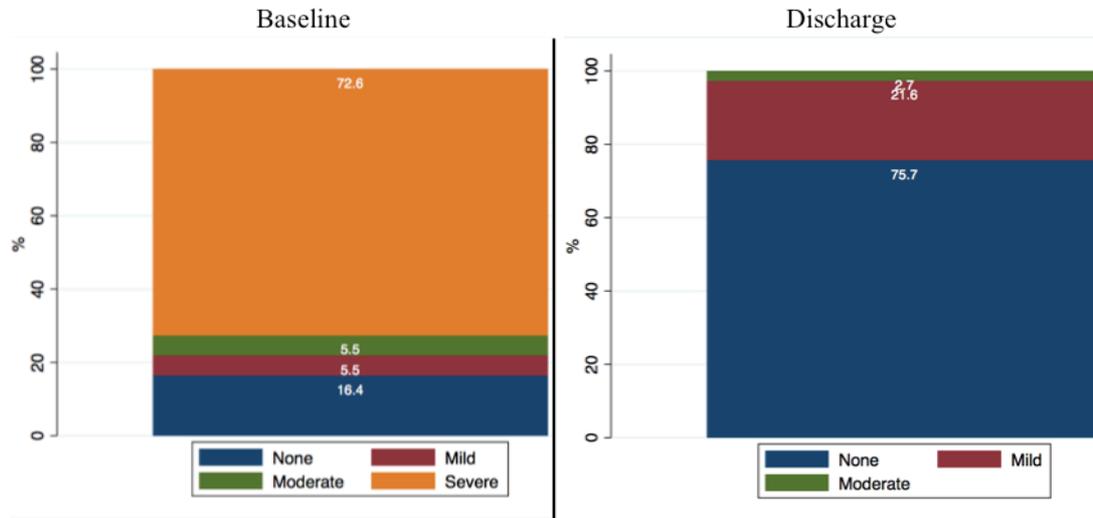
Comparison of basal and pre-discharge of tricuspid regurgitation (A), “pulmonary” regurgitation (B) percent distribution of differential grading in the study population. Figure 2C reports comparison of basal and pre-discharge peak echocardiographic gradient across RVOT in the study population.
